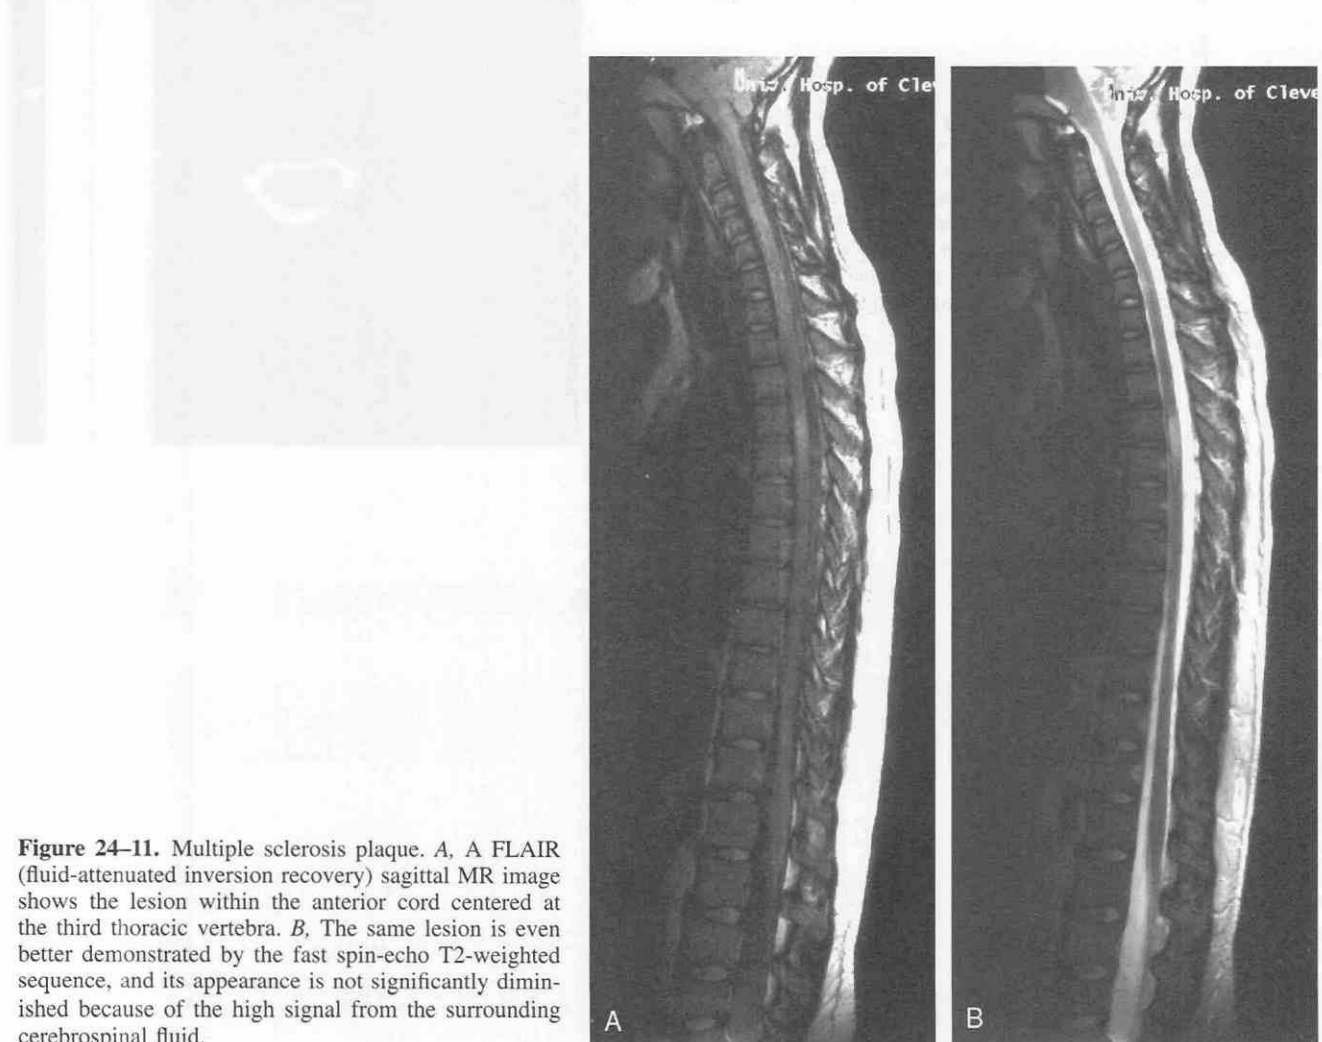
Multiple sclerosis plaque. A, A FLAIR (fluid-attenuated inversion recovery) sagittal MR image shows the lesion within the anterior cord centered at the third thoracic vertebra. B, The same lesion is even better demonstrated by the fast spin-echo T2-weighted sequence, and its appearance is not significantly diminished because of the high signal from the surrounding cerebrospinal fluid.
